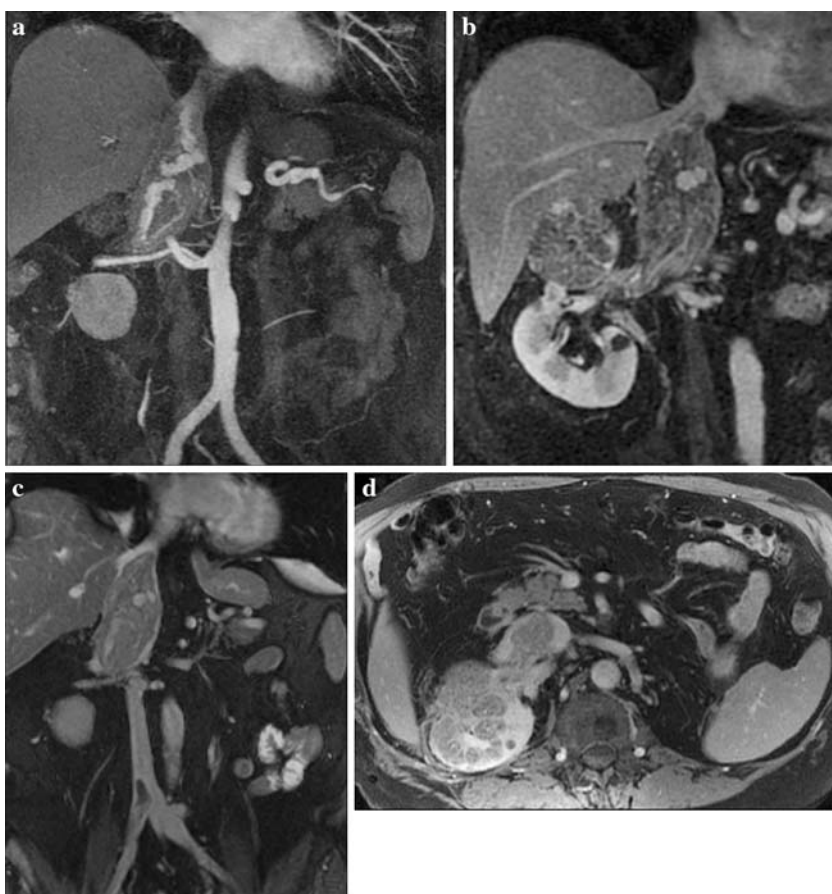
Versatility of MRI in staging renal cell carcinoma. Coronal arterial phase (A) image from 3D fat-saturated SPGR sequence revealing two right renal arteries as well as enhancing tumor vascularity in the IVC. Venous phase image from same sequence (B) reveals large upper pole right renal mass with thrombus expanding the right renal vein and IVC. Coronal image from a noncontrast fat-saturated steady state free precession sequence (C) depicts additional bland thrombus in the IVC at the bifurcation. Axial postcontrast fat saturated SPGR image (D) again reveals large renal mass with renal vein and IVC tumor thrombus.
